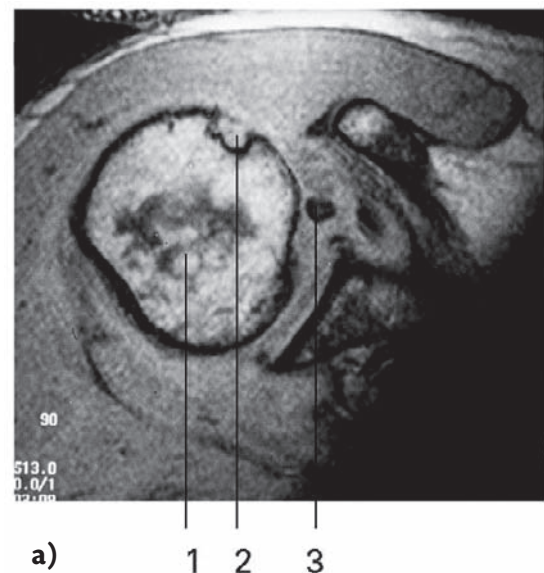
Dislocation (luxation) of the long tendon of the biceps muscle. a) Magnetic resonance imaging (MRI) of the upper arm (1) will secure the diagnosis. Here is a picture showing an empty groove (sulcus) in cross section (2) and the biceps tendon clearly moved medially inward towards the joint (3); b) location of tenderness on palpation.
